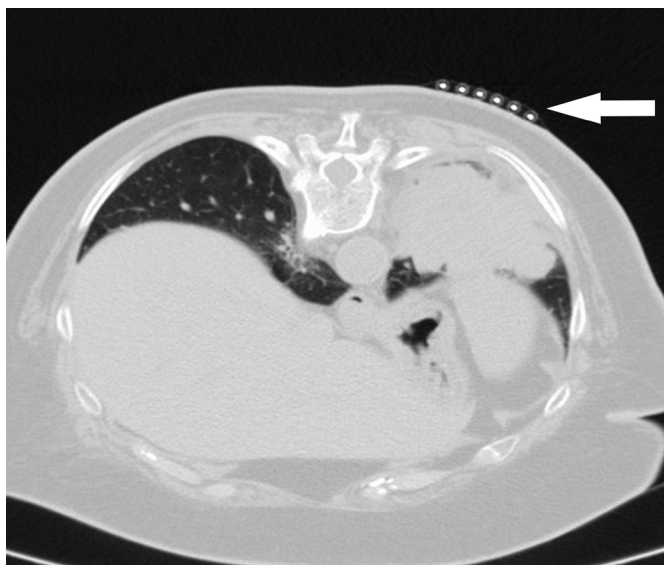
CT-guided PCTTB from left lower lung mass. Preprocedure scan with a grid on the skin is also shown. . (white arrow)
